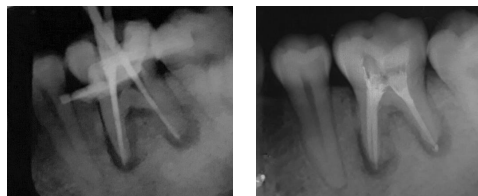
(a) Master cone length radiograph (b). Radiograph showing obturation of tooth 36
